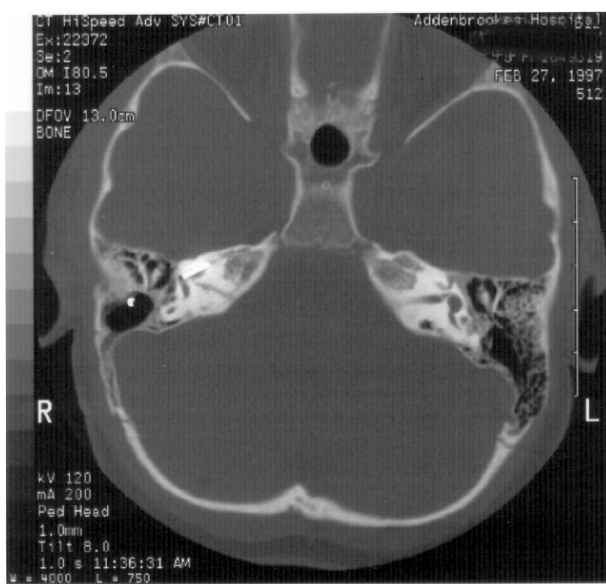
Ultra high definition CT scan (axial view) showing narrowing of IAMs on both sides (Patient).
